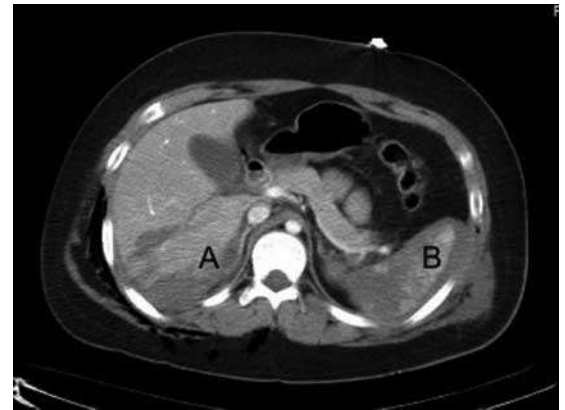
Computed tomography image of a grade III liver haematoma (A) and grade IV splenic haematoma (B), with minimal free fluid.²⁶ The patient was managed without surgery
